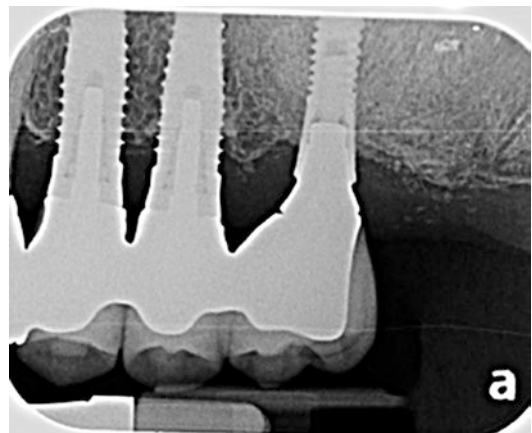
Radiographic appearance at 1 year suggests no change in crestal bone levels or possible improvement (distal of implant #15)
